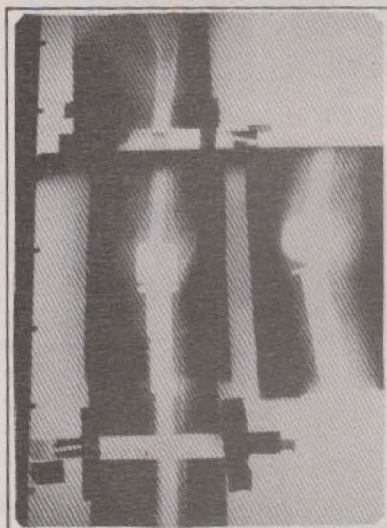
Showing Case 1 (g) X-rays after Surgery
